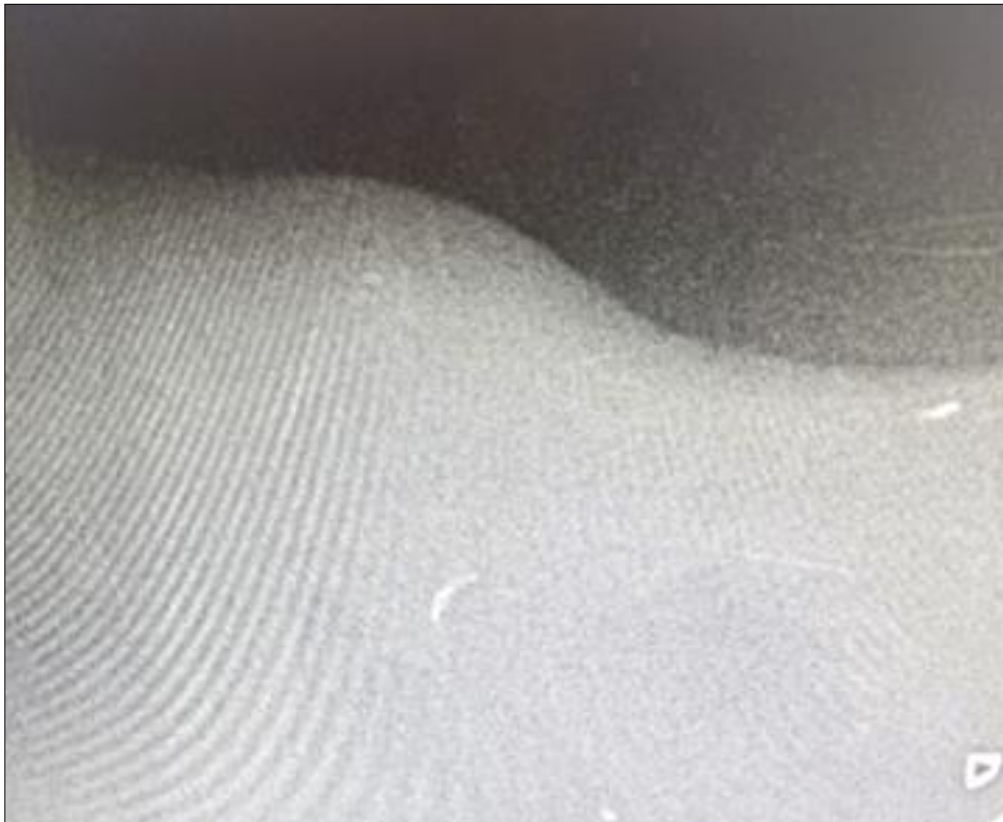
Radiograph of the lower lip showing absence of foreign body.
